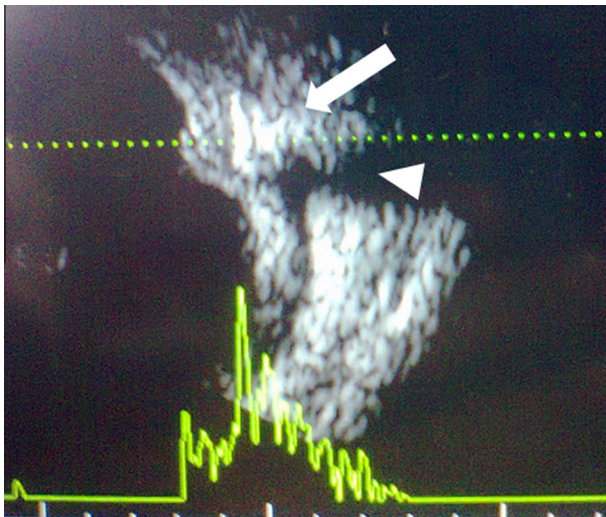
Ultrasound B Scan image depicting the foreign body in thickened ocular coats (arrow) seen as a hyperechoic lesion with 100% reflectivity and posterior acoustic shadowing (arrow head).
